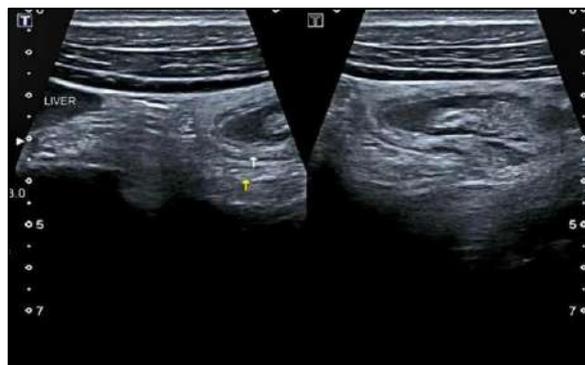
Ultrasound Image Showing a Subhepatic Appendix with Echogenic Mesentery.
